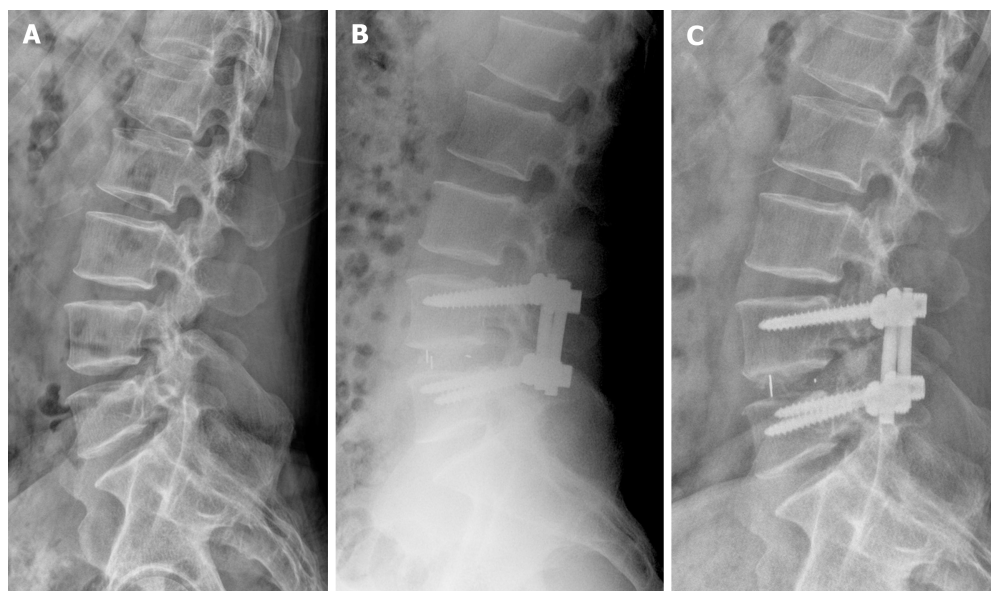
X-rays of a patient who underwent transforaminal lumbar interbody fusion surgery. A: Male, 51 years, lumbar disc herniation; B: postoperative X-ray: Pelvic incidence (PI) 57°, lumbar lordosis (LL) 59°, Lower lumbar lordosis 32°, |PI-LL| 2°, lordosis distribution index 54.2%; C: 27 months after the operation: Retrograde distance of cranial adjacent segments 4mm.
